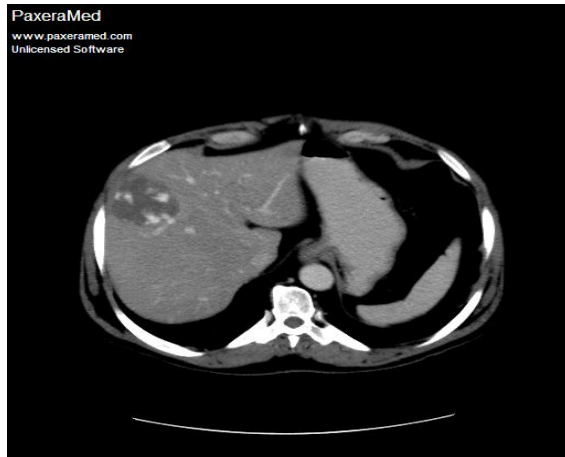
40 yrs Male axial CT image arterial phase show prephral enhancement of heamangioma
